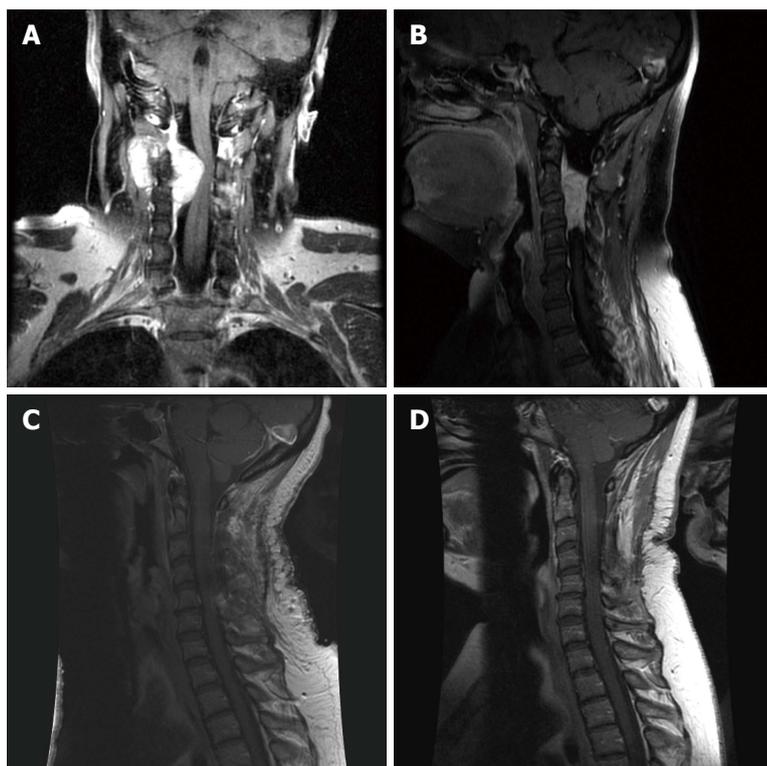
Pre-operative magnetic resonance imaging of the cervical spine. On coronal (A) and sagittal (B) view showed an extradural soft tissue mass at C2-C4 levels. After debulking of the mass (C) and at 10 mo post-operative follow up (D) showed markedly decreased mass effect on the cervical cord.
